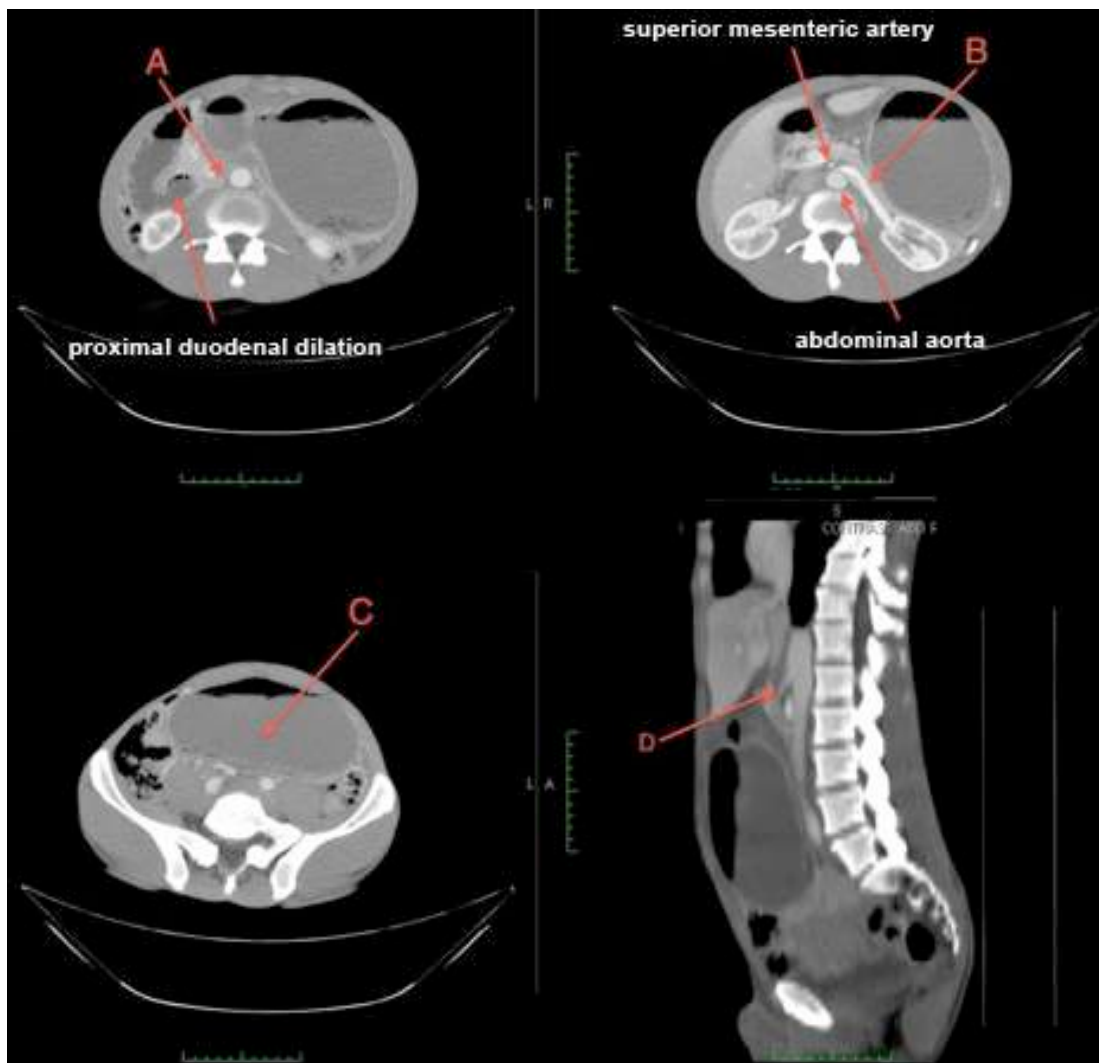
Computed tomography of the abdomen and pelvis demonstrating compression of the duodenum between the abdominal aorta and superior mesenteric artery (A), dilation of the left renal vein (B), distension of the stomach (C), and the aortomesenteric angle (D).
